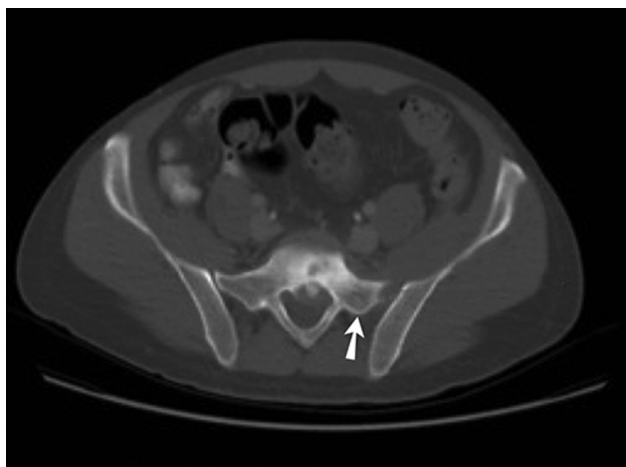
Axial CT scan image with bone windowing shows another focal expansile lytic lesion in the first sacral vertebra (arrow).
